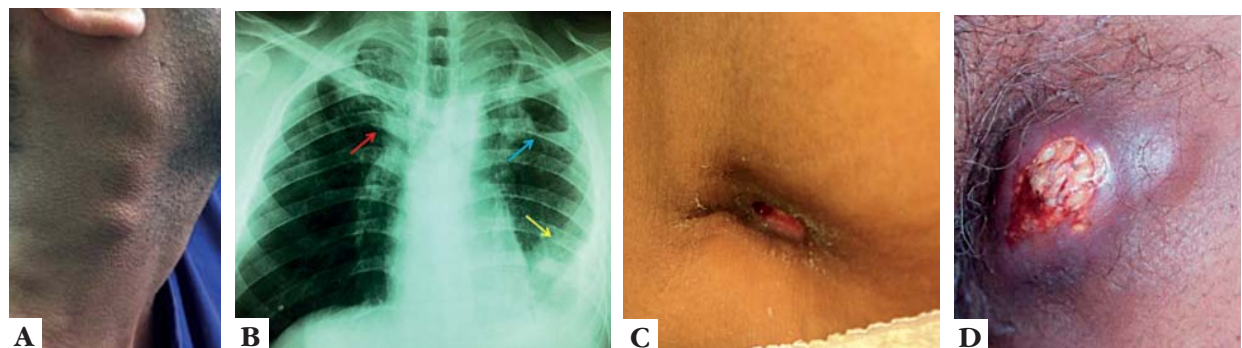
A. Scrofuloderma (Courtesy from Dr. Vitor Paulo Perez - Fiocruz); B. Chest X-ray in posterioranterior (PA) position showing a right infraclavicular opacity (red arrow), images of thick-walled cavities, acinar lesions permeating the left superior lobe (blue arrow) and pleural effusion on the left (yellow arrow). Pulmonary tuberculosis – Chest X-ray from the same patient on Figure 3 (Courtesy from Dr. Vitor Paulo Perez - Fiocruz); C. Scrofuloderma (Courtesy from Dra. Julia Ocampo Lyra da Silva - Bonsucesso Federal Hospital); D. Scrofuloderma. Ulcerated nodular lesion on the left inguinal region of an HIV positive patient
